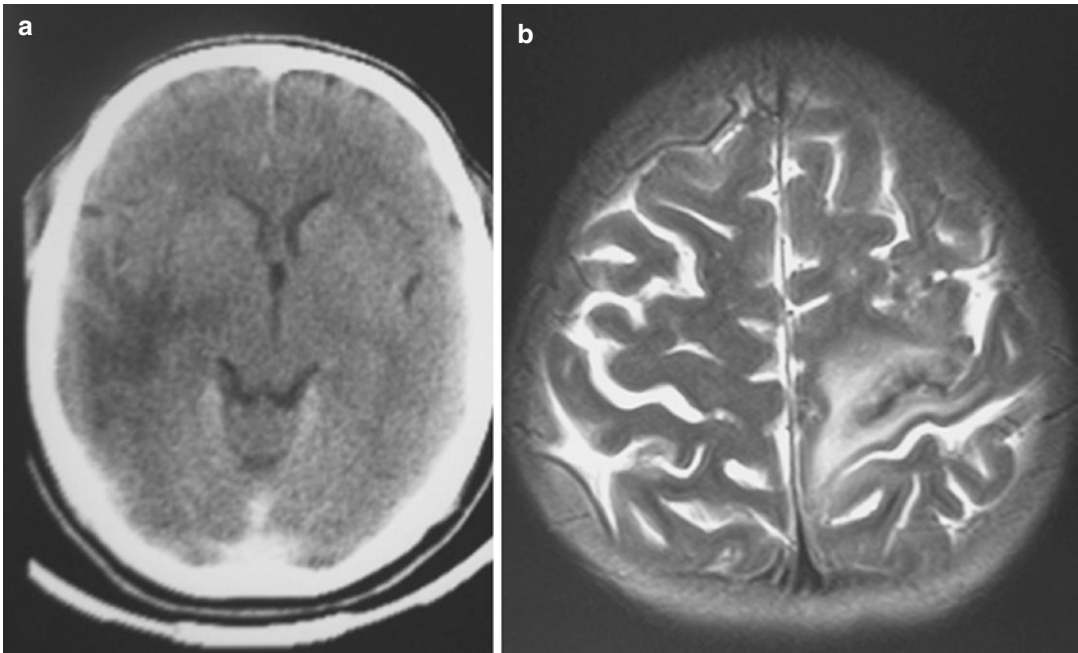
TB cerebritis. (a) Axial post-contrast CT image demonstrates an irregular hypodensity in *right* temporal region with faint peripheral enhancement in anterior
